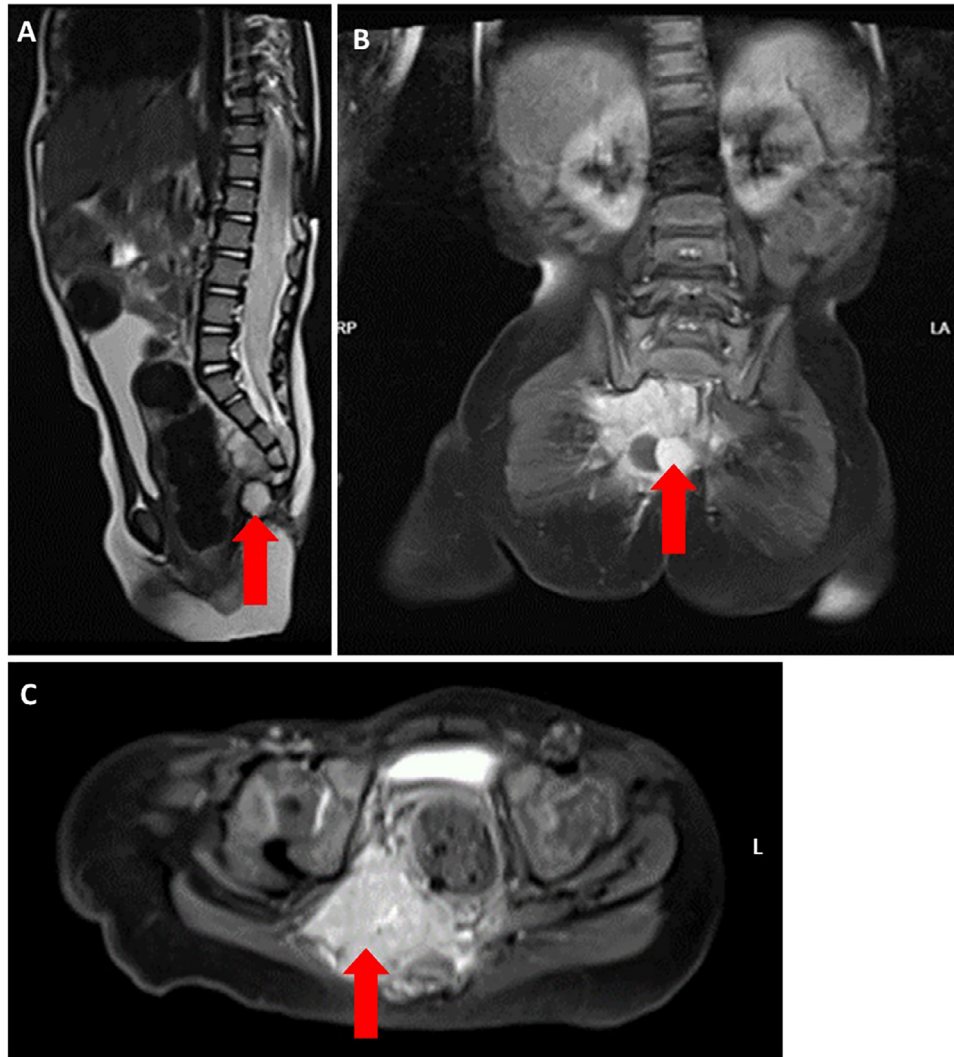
MRI abdomen-pelvis showing a presacral lesion measuring 3.8 × 4.5 × 4.1 cm (red). It was infiltrating the right sacral nerve root, protruding into the right greater sciatic foramen and abutting rectosigmoid reflection and gluteus muscles with areas of necrotic changes and granulation tissue on surgical bed, coccygeal cutaneous and postsurgical changes.
